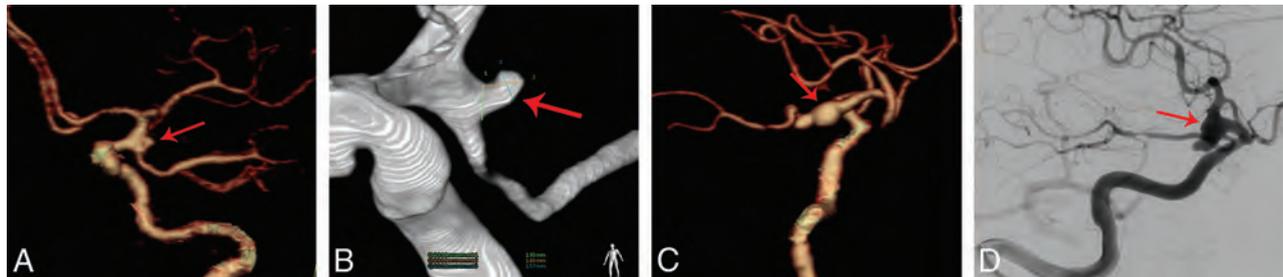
Comparison of the 2 CTA protocols for detecting an aneurysm in the posterior communicating artery. A and B, An 80-kVp cerebral CTA with 30 mL of contrast agent in a 49-year-old woman. A volume-rendered digital subtraction CTA image (A) shows an aneurysm in the left posterior communicating artery (red arrow), which is confirmed by 3D-DSA (B). C and D, A 120-kVp cerebral CTA with 60 mL of contrast agent in a 66-year-old woman. C, Volume-rendered digital subtraction CTA image (C) shows an aneurysm in the right posterior communicating artery (red arrow), which is confirmed by 2D-DSA (D).
